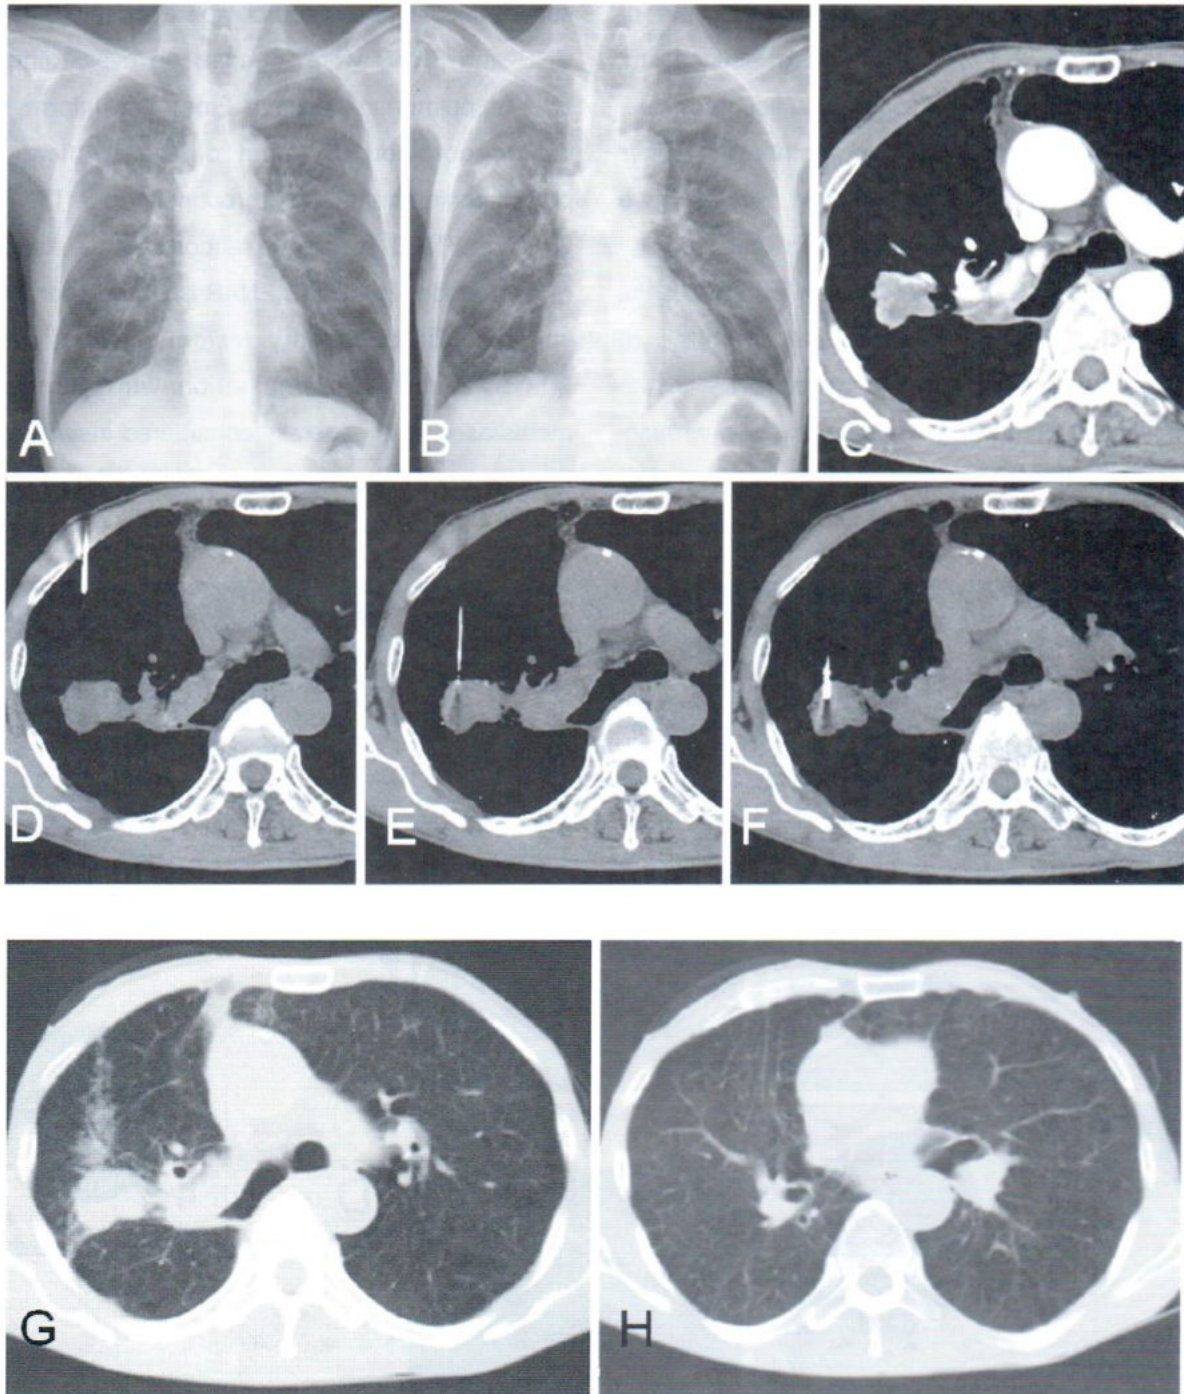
A 70 years old man presented with developing of RUL mass from May 2008 (A) to February 2009 (B). CT scans of chest was done and showed enhancing mass at RUL. Percutaneous transthoracic Core needle biopsy was performed by using Semi automatic cutting devices No.18 G X I attempt (D, E, F) and pathological report showed bronchoalveolar carcinoma (BAC). CT scans of chest after TTNB (G, H) showed pulmonary hemorrhage along the needle tract. No pneumothorax was observed.
